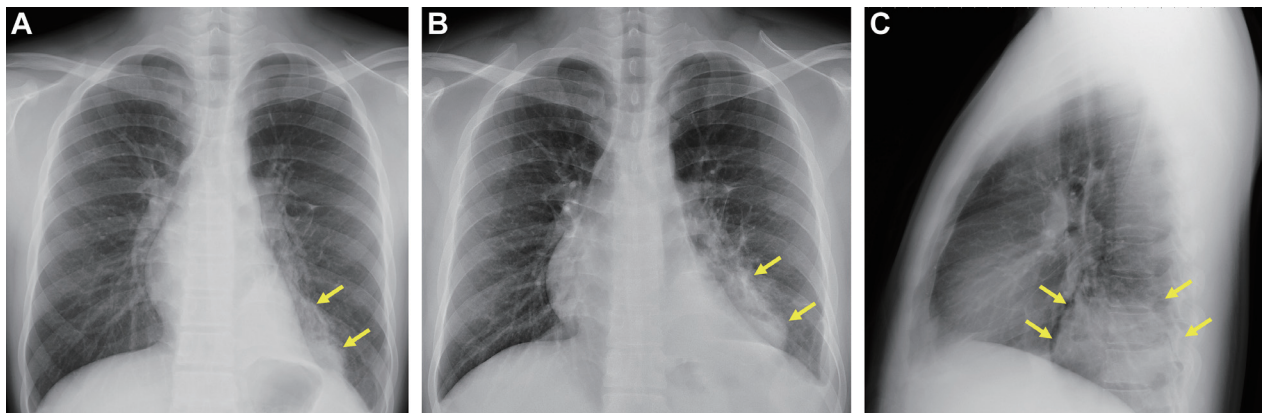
Chest radiographs revealed repeated pneumonia in the left lower lobe (LLL) (arrows). (A) Chest radiograph on the occasion of LLL pneumonia 10 years prior to this admission. (B,C) The posteroanterior (B) and lateral (C) chest radiographs taken on the most recent admission showed LLL pneumonia.
